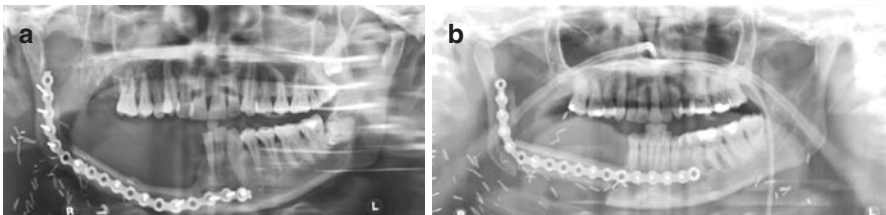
Two post-reconstruction orthopantomograms, showing our initial low (a) and current higher (b) approach to inset of the fibula. The lower position affords a more aesthetic jawline, but compromises the placement of implants by requiring greater length and associated greater torque. The higher position allows easier dental rehabilitation
